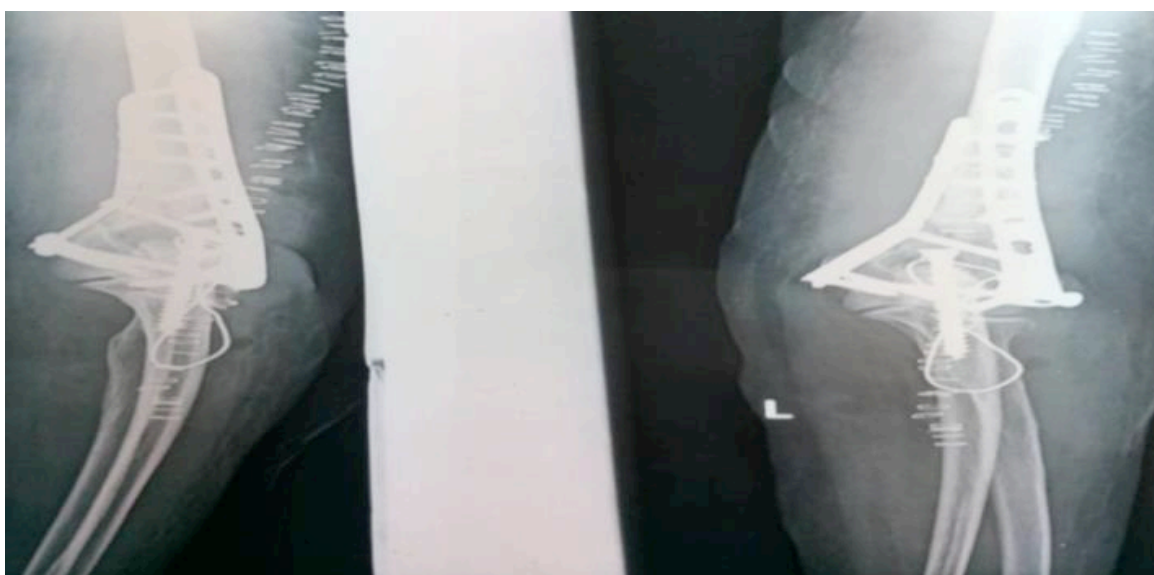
Immediate post op x-rays
